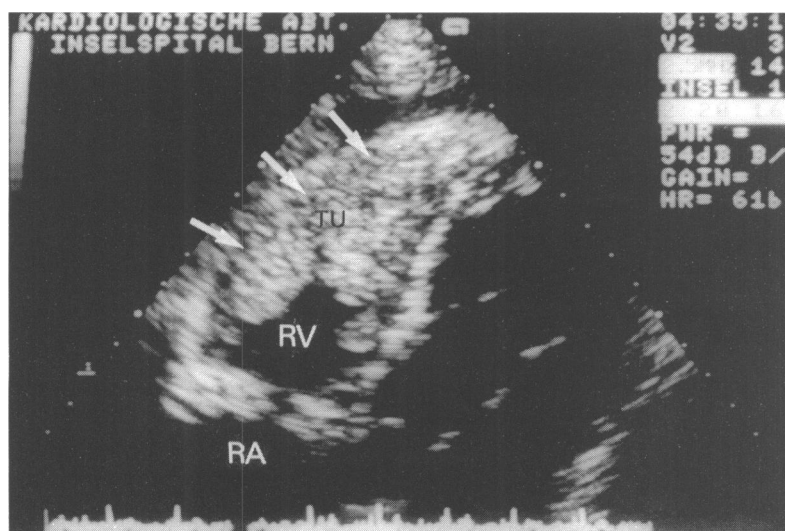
Apical four chamber view of a transthoracic echocardiogram showing a tumour (TU) in the right ventricle with the extensive infiltration of the right ventricle wall (arrows). RV, right ventricle; RA, right atrium.
